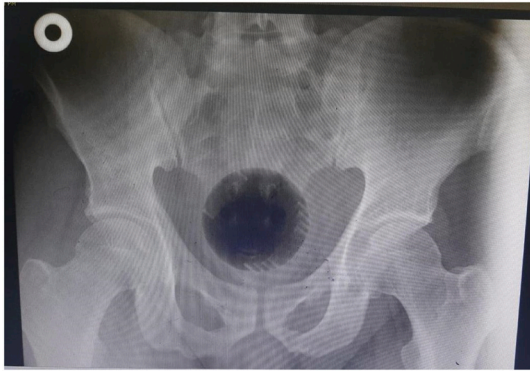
X-ray showing a round-shaped foreign body in rectum.
